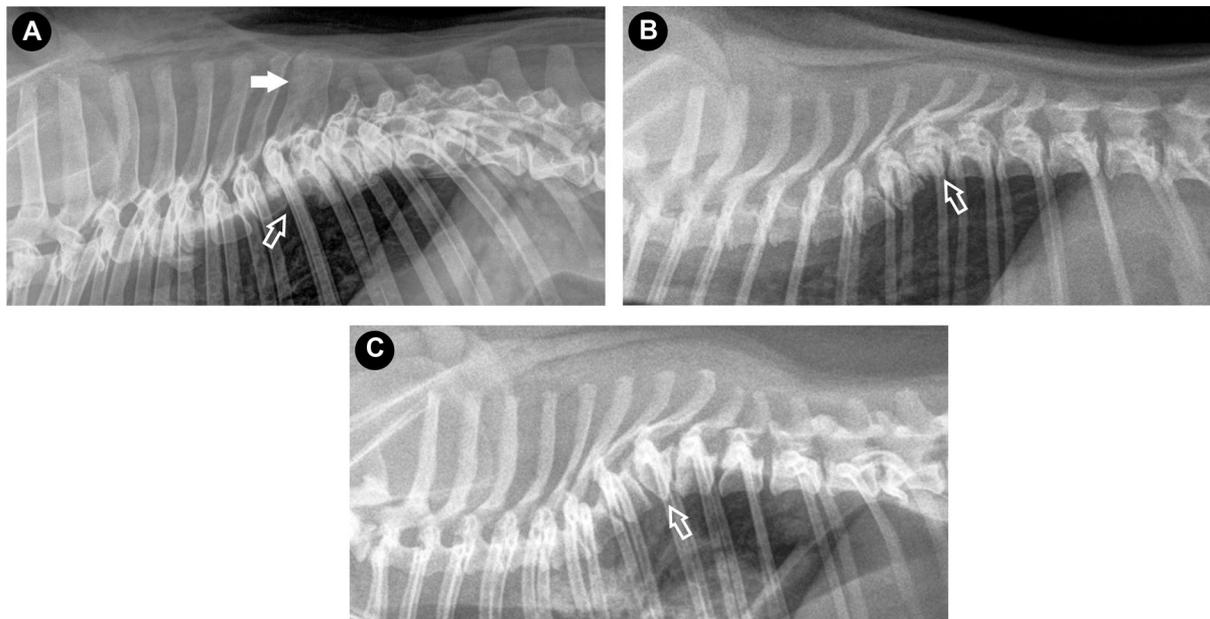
Congenital vertebral malformations identified on lateral radiographs of the thoracic vertebral column. (A) Block vertebrae, where there is failure of normal segmentation of the vertebrae, evident as the failure of division of T8 and T9 vertebral bodies (open arrow) and spinous process (solid arrow). (B) Ventral hypoplasia of T8 vertebral body (ventral wedge shape vertebra) (arrow) with kyphosis. (C) Ventral aplasia of T8 vertebral body (dorsal hemivertebra) (arrow) with more severe kyphosis.
